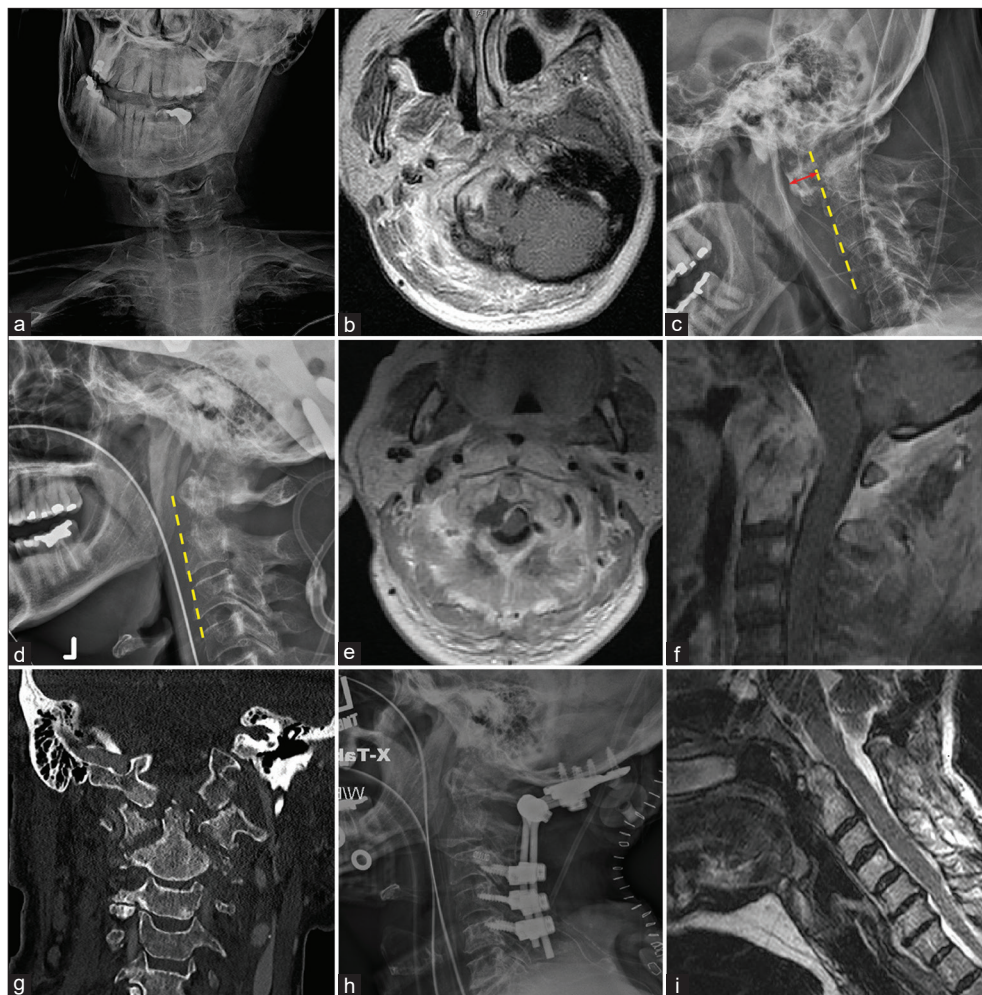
Case 1: X-ray of the neck demonstrating cock-robin position (a); T1 magnetic resonance imaging (MRI) of suboptimal quality due to neck tilt (b); lateral X-ray of the craniocervical junction showing increased atlanto-dental interval marked by the red arrow (c); post traction imaging demonstrating complete reduction on lateral X-ray (d) with extensive inflammation seen on axial (e) and sagittal (f) T1 MRI and coronal computed tomography (g) of the cervical spine; postoperative lateral neck X-ray (h); and sagittal T2 MRI (i) demonstrating proper instrumentation and alignment. Yellow dashed line indicates anterior alignment of the cervical spine.
